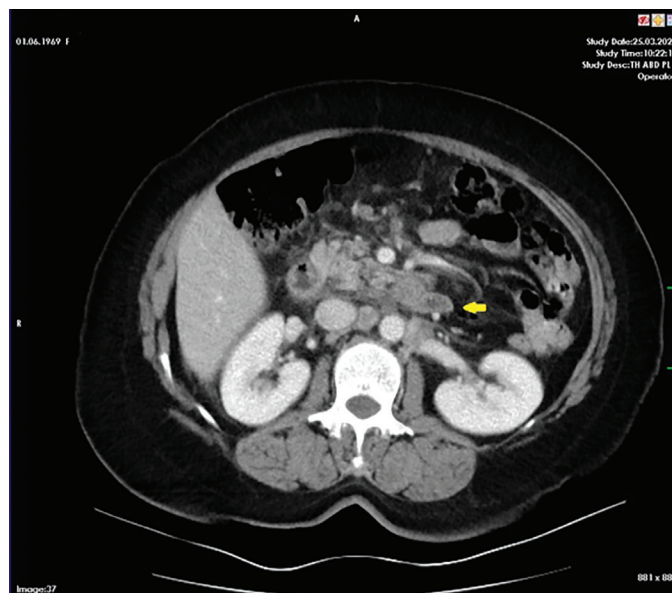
CT after completion of six cycles of mFOLFIRINOX demonstrating partial radiologic response
